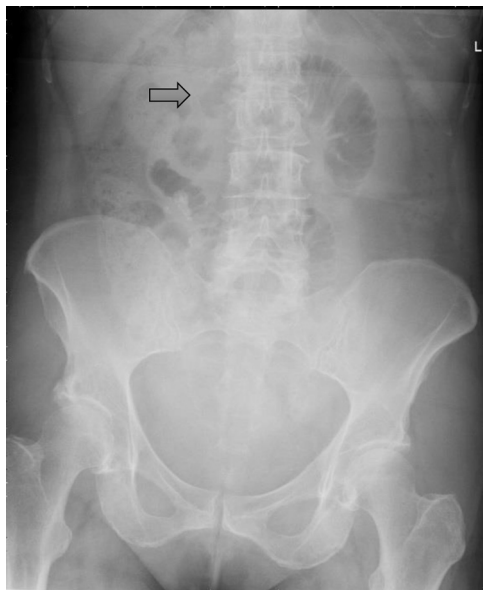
Plain abdominal radiograph. Two dilated loops of small bowel are seen (arrow).
